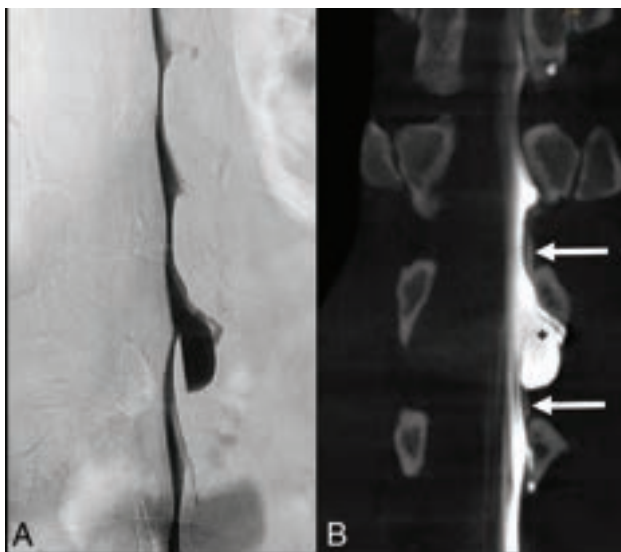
A 47-year-old man with SIH, resulting in bilateral subdural hematomas. DSM with the patient in left lateral decubitus position does not demonstrate a contrast extradural outflow at the level of a suspicious meningeal diverticulum at L1/2 (A). Subsequent CBCT in a coronal reconstruction reveals a subtle extradural contrast collection next to the diverticulum (arrows in B), confirming a slow-flow type 2 leak. The high spatial resolution of CBCT also indicates an accompanying arachnoid outpouching with an interrupted dura (medial-cranial to the *asterisk* in B), appearing like a meningeal diverticulum (later confirmed by surgery). CBCT settings are the following: 3D-(5sDCT Body), 49-cm zoom, 90 kV, 544 mA, 90 images/sec in a 4.83-second runtime (397 total images).
